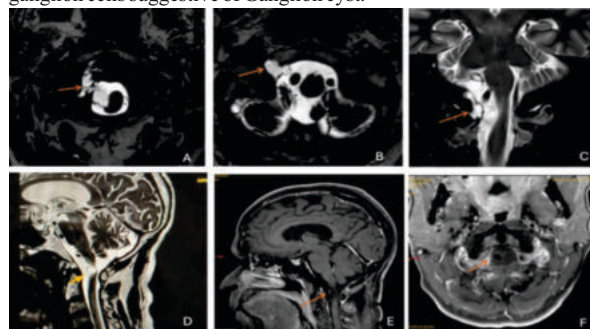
(A) T2W axial section at CV junction showing T2 hyperintense cystic intradural lesion pushing the cord to the left and the orange arrow indicates the extradural component, (B) T2DRIVE axial section at CVJ showing the extradural portion of lesion extending into hypoglossal canal, (C) T2MRI coronal section showing the extra axial lesion pushing the cord to the left, (D) MRI T2W mid sagittal section of CVJ showing T2 hyperintense lesion at cervico-medullary junction (yellow arrow), (E) sagittal section and (F) axial section of CVJ post contrast images showing minimal peripheral rim enhancement
